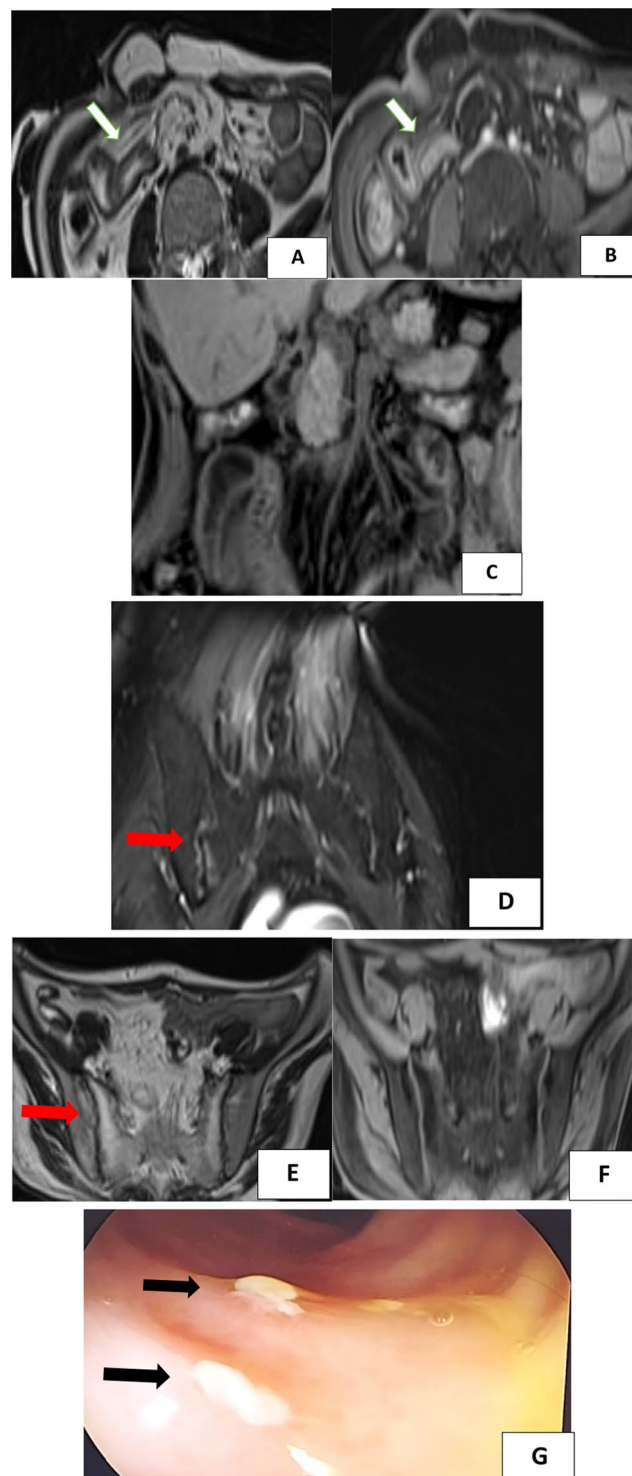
(Case 2) A 33-year-old male patient, presented with status follow-up of a known case of Crohn's disease post-right ileostomy operation, ultrasound was performed with no conclusive data, MRE was performed. Axial T2WI and axial T1 Dixon post-contrast with FS images A, B, coronal T1 Dixon with FS C, show circumferential mural wall thickening at the distal ileum with stricture formation and minimal fibrotic streaks at the operative bed, enhancement of mural wall thickening, clear surrounding fat planes (white arrows). No perilesional collection. Coronal T2 Dixon with FS with contrast (water only) D, axial T2WI, axial T2 Dixon with FS (water only) E, F show bilateral sacro-iliitis in the form of subchondral bone marrow fatty changes display high T2WI signal intensity and suppressed its signal in Dixon with FS (red arrows), enhancement in post-contrast of subchondral bone marrow areas of altered signal intensity. Endoscopy image G showed few ulcerations of terminal ileum (black arrows). Denoting recurrence of the disease
